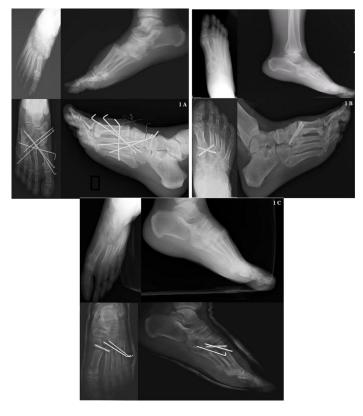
Preoperative and postoperative X-ray examples of 3 different fixation methods. 1A, K-wire fixation. 1B, screw fixation. 1C, screw and K-wire fixation
